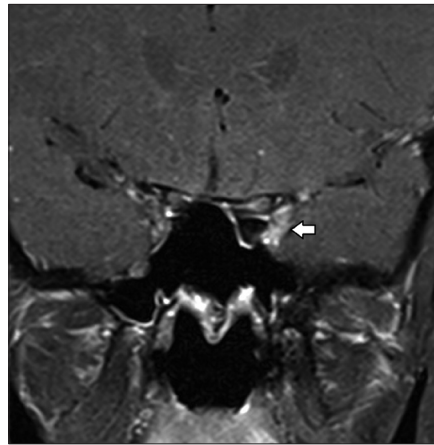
T1-weighted contrast-enhanced image of the brain shows thickening and enhancement of the left V1 (first branch of trigeminal nerve) (*left arrow*).
